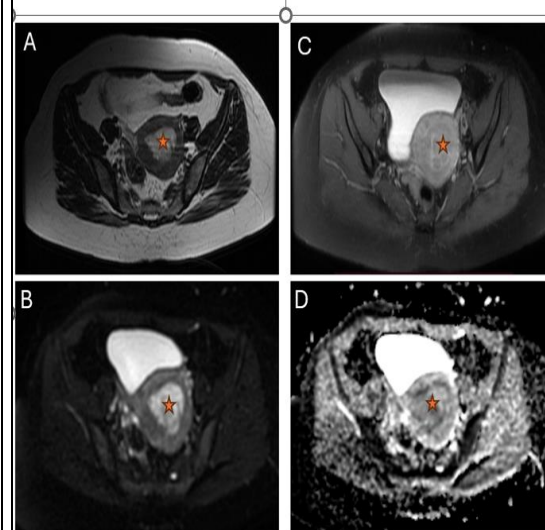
Ca endometrium (*) - shows hyperintense signal on Axial T2W images (A). (C) Axial T1 postcontrast images shows mild heterogeneous enhancement (B) DWI images reveal high signal with low signal on ADC map (D).
